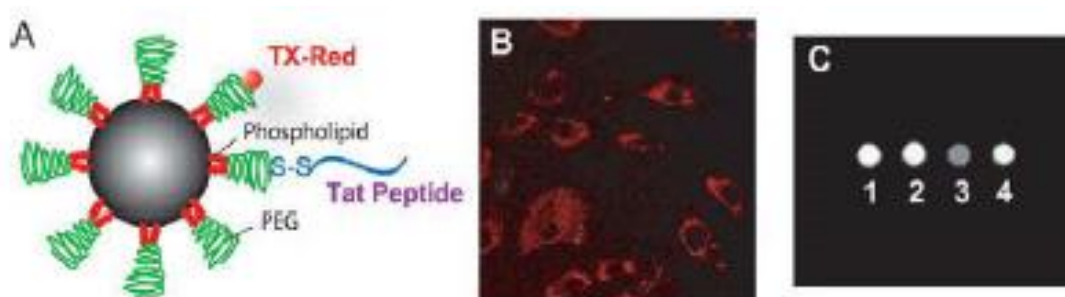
(A) Micelle-encapsulated SPIO conjugated with Tat peptide and the fluorescent label Texas Red (TX-Red). (B) Fluorescent images of Tat-linked, TX-Red labeled SPIOs in human dermal fibroblast cells. (C) MRI images of (1) culture media only, (2) cells without SPIOs, (3) cells with SPIOs, (4) culture media only. [96]
